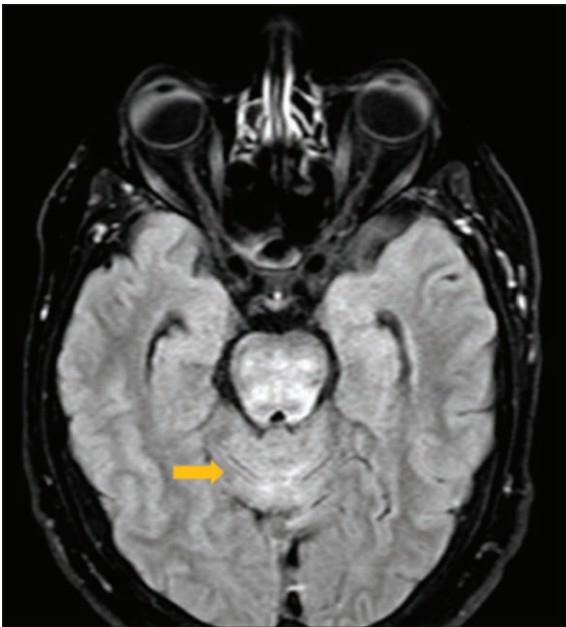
Brain magnetic resonance imaging: hyperintense lesions in T2/FLAIR at pons and vermis.
